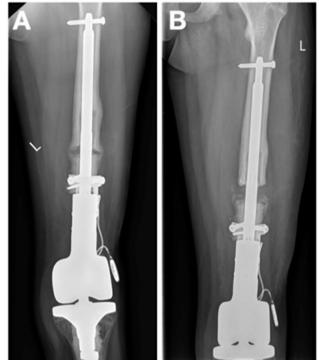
Anteroposterior (A) x-ray images demonstrating the MUTARS[®] BioXpand implant in situ with bony fusion of the callus encountered during follow-up visit and status after re- osteotomy and elongation by 1 cm (B)
